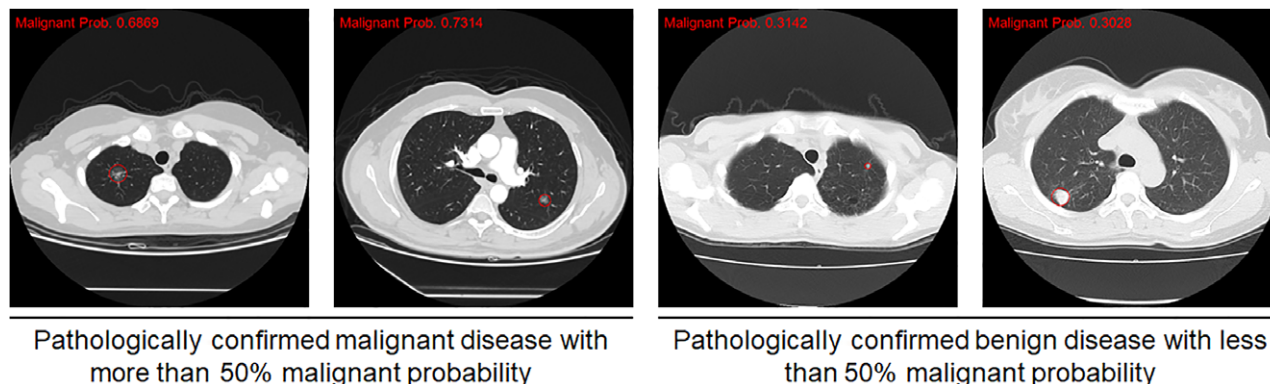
Final output performance from our proposed system. Four computed tomography images containing pathologically confirmed malignant or benign disease are presented. The target nodules will be automatically circled out and given probability value of malignance. If value was more than 50%, it was considered malignant disease, whereas it was the opposite for those less than 50%.
